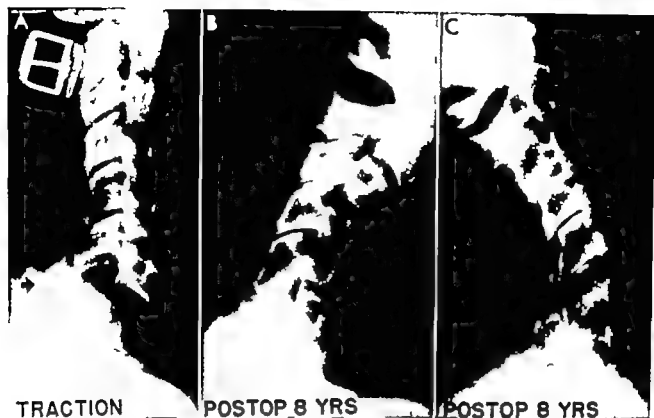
A, a complete anterior dislocation of the sixth cervical upon the seventh cervical vertebra. Symptoms of partial loss of cord function were observed immediately after the injury. Improvement neurologically was noted very shortly afterward. Reduction was easily completed at operation after several days of halter traction. B, result after 8 years. Roentgenogram made in maximum flexion. C, maximum extension. Fusion was solid. No neurological symptoms and no complaints. Patient carrying on full preinjury activities as a dairyman. (This figure is reproduced from *The Journal of Bone and Joint Surgery*.)
